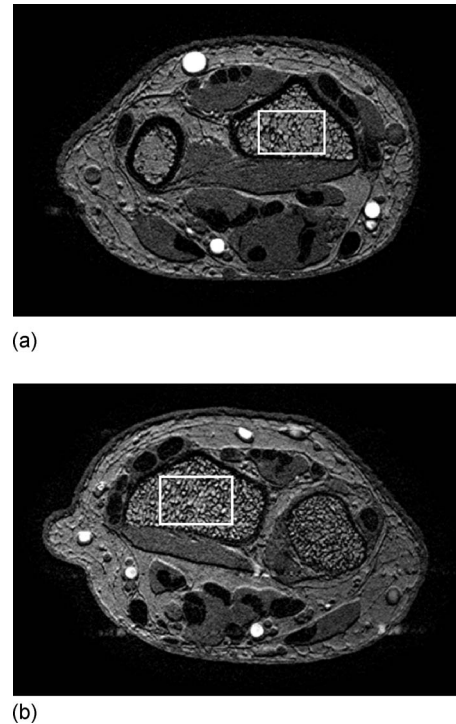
Example of two acquired axial images with the 3D spoiled T1-weighted gradient echo sequence and corresponding selection of the ROI in one slice. Wrist slice corresponding to the acquisition performed in a left-handed 64 yr old female patient with osteoporosis (a). Image corresponding to a series acquired in a right-handed 62 years old female healthy volunteer (b).
